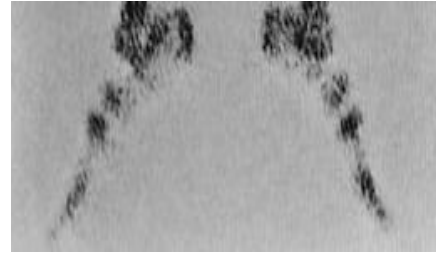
Bone scintigram showed an area of the hypointensive radiotracer in lateral parts of the both tarsal scaphoids.
